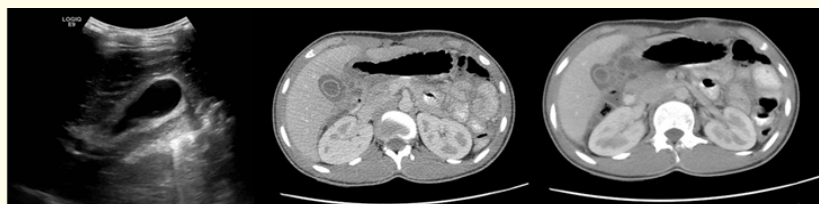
US and CT scan showing thickening of the gallbladder and fluid.
